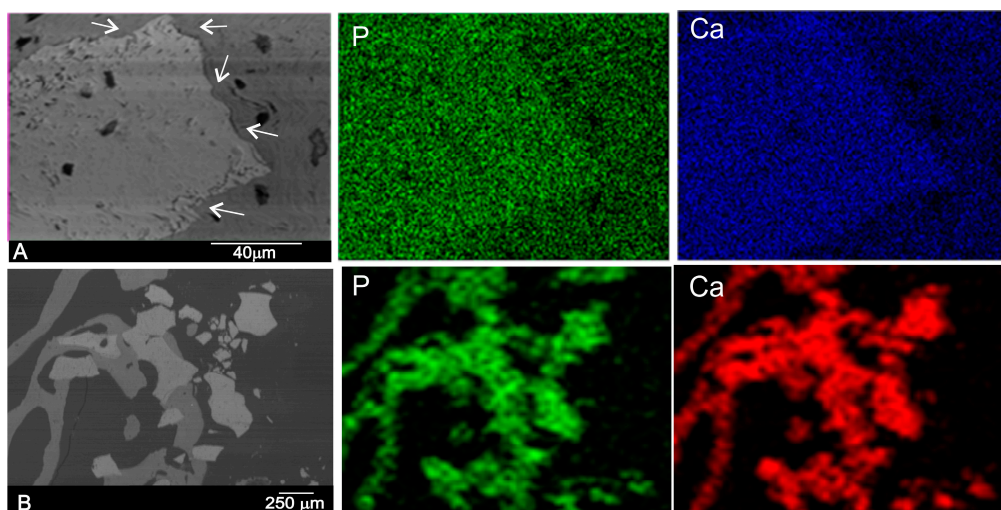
SEM image of the polished cross-section of a biopsy of the (A) DBHa and (B) DPHa xenograft material six months after implantation and the elemental X-ray maps of calcium and phosphorous (arrows refer to the irregular boundary with a partial degraded implant).
